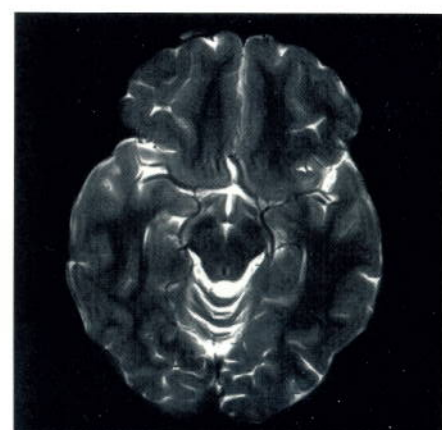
FatSat Turbo Gradient Spin Echo T2-weighted pediatric head, sequence used was tgse21_132b150.wkc, TR 5016 ms, TE 132 ms, Flip 180 deg, FOV 200 mm, RecFOV, Swap, matrix 378 x 512o, slice 5 mm, 2 acquisitions, scan time 6+ min, F:9 image filter. (Courtesy of Childrens Hospital of Philadelphia)
